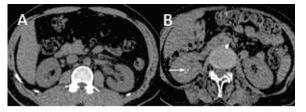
Standard dose axial view of CT-KUB (120 kVp and effective dose of 12mSv) Figure 5B: Low dose axial CT-KUB (100 kVp and effective dose of 2 mSv). Despite high image noise, small calculus (<3mm) is still visible. (arrow)
